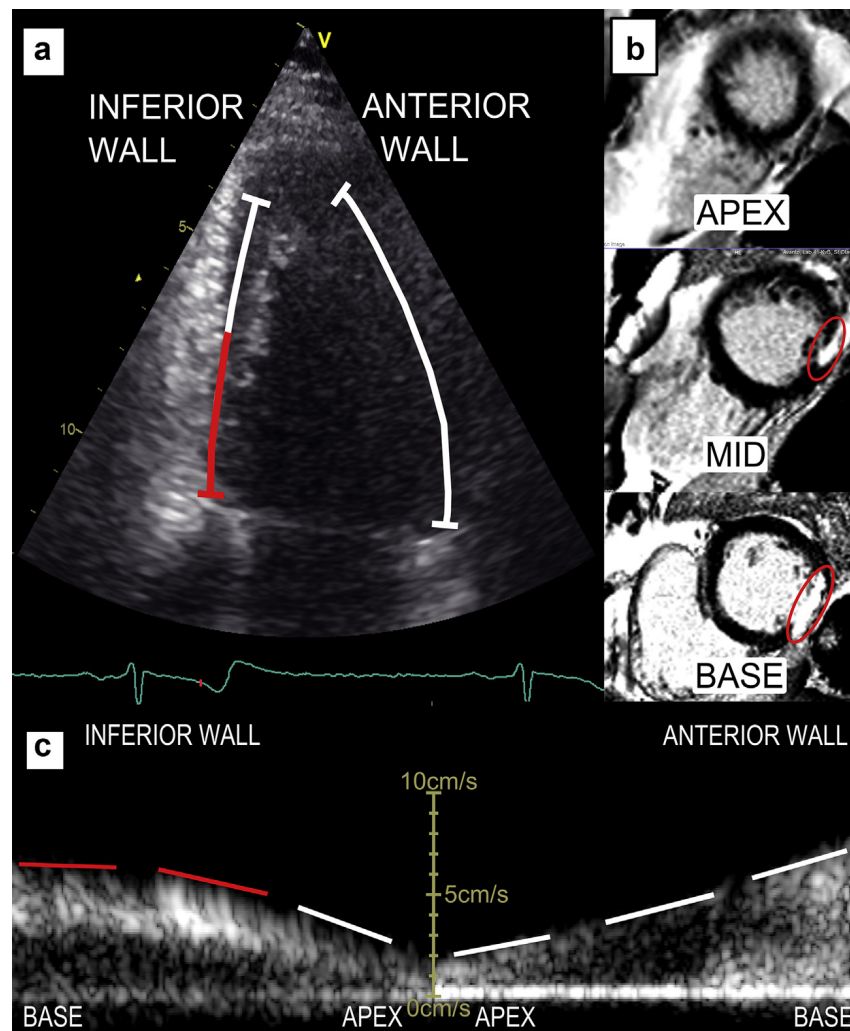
Anatomic Doppler spectrum (ADS) from anterior and inferior wall in a patient with an inferior wall infarction. (a) B-Mode image and anatomic curve forming the basis for the ADS. (b) Late gadolinium-enhanced magnetic resonance image from the same patient. The infarcted area is visible as enhanced scar in the basal and midventricular inferior wall (demarcated with red ring). (c) The ADS has nearly the same slope in all anterior segments, despite low signal (lung or bone shadow). In the inferior wall, there is almost no slope in the basal segment, reduced slope in the middle and normal slope in the apical segment. This corresponds to the scar distribution seen on the late gadolinium-enhanced magnetic resonance image to the right.
